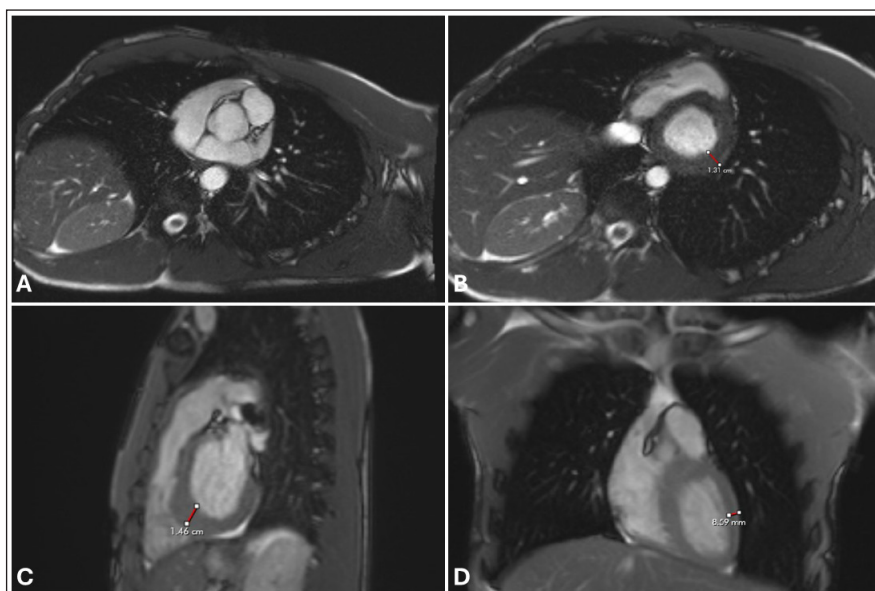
Cardiac magnetic resonance imaging showing findings within normal limits.
